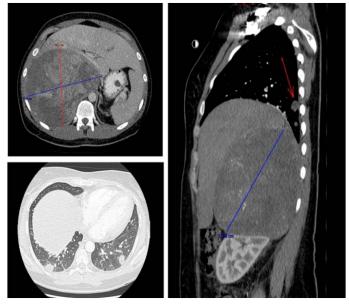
Initial CT-scan: voluminous right supra-renal mass of 17x15 cm. Multiple pulmonary nodules.
